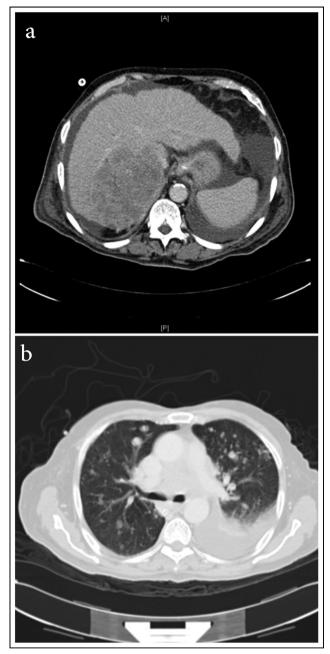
(a) CT abdomen demonstrating moderate ascites and large tumor mass in the right lobe of the liver $(9.6 \times 9.8 \times 11 \text{ cm})$. (b) CT chest showing right pleural effusion and multiple bilateral metastatic lung nodules.
